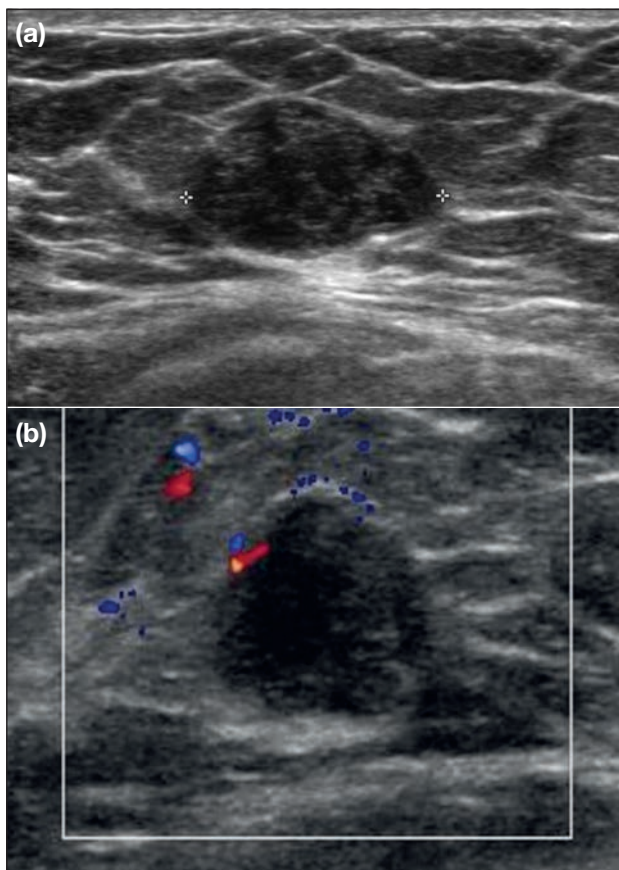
Benign phyllodes tumour of right breast in a 42-year-old woman. (a) Axial ultrasonogram showing a 2.0-cm well-defined oval mass with heterogeneous echogenicity and multiple small anechoic clefts. (b) Colour Doppler ultrasonogram of longitudinal view showing focal increased peripheral vascularity.
